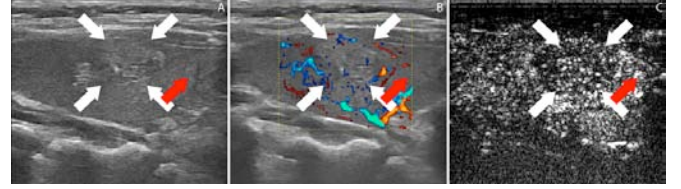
A) HRUS, B) Color Doppler, C) CEUS images of a goiter nodule (benign).
